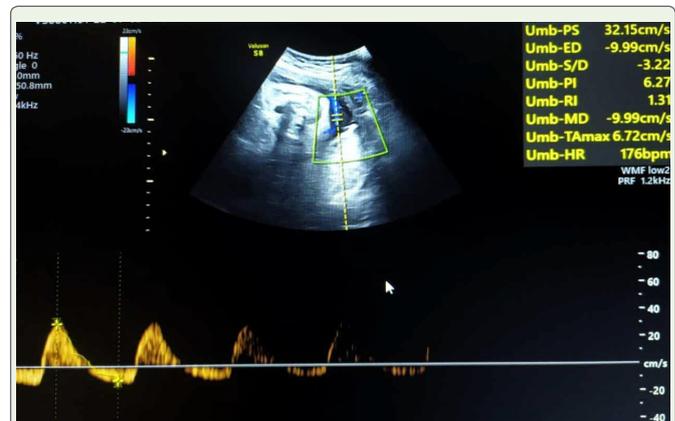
Umbilical artery doppler at 36 weeks of pregnancy shows reversed end-diastolic flow.
